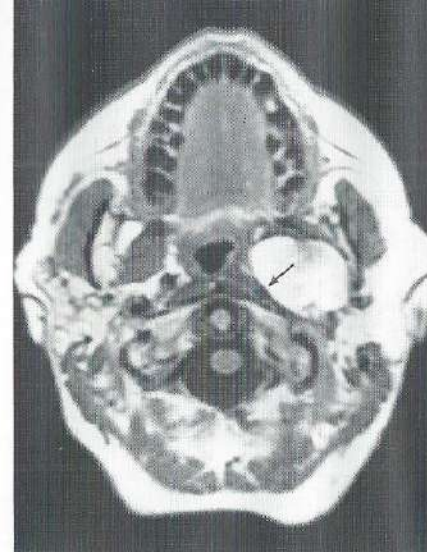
This MR T1-weighted SE image shows a well circumscribed tumour of the parapharyngeal space with a high signal intensity. It is located anterior to the internal carotid artery leaving it in a normal position (arrow).
